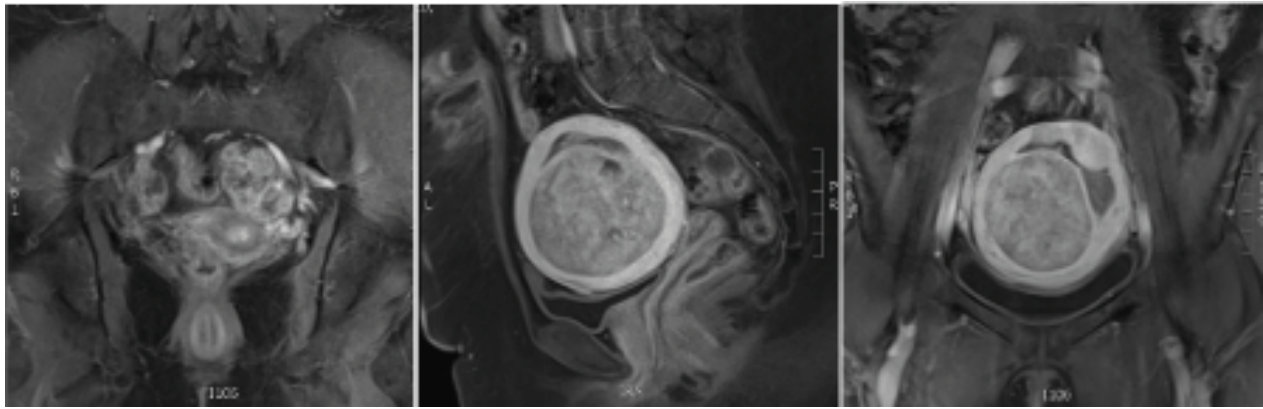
Sagittal (Right) and axial (middle) and coronal (left) MRI images of the abdomen and pelvis demonstrate a markedly enlarged and heterogeneous uterus with a complex bilateral adnexal mass.
